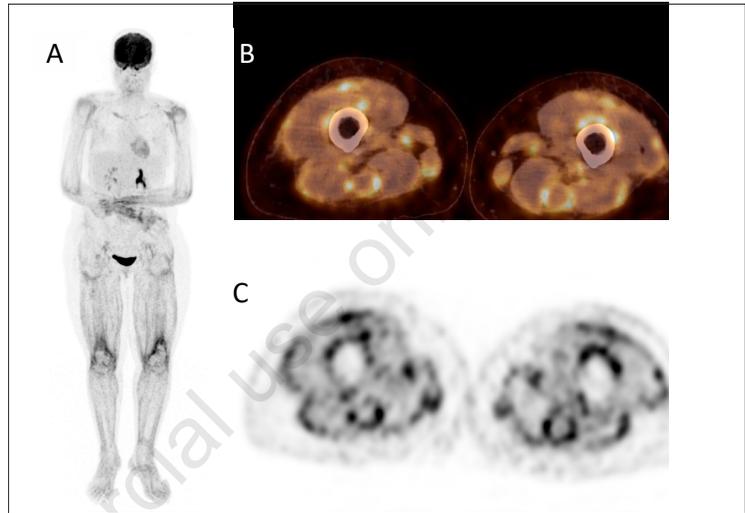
^{18}F FDG-PET/CT shows diffuse and symmetrical increased uptake in the fasciae of the upper and lower limbs, sparing both muscles and fat tissues on ^{18}F -FDG MIP images (A) as well as in ^{18}F -FDG PET-CT fusion (B) and ^{18}F -FDG PET alone (C).
